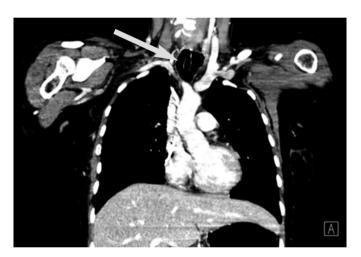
Angio-CT thoracic scan, coronal section, before the surgical intervention: Highlighting the tracheo-oesophageal fistula.
